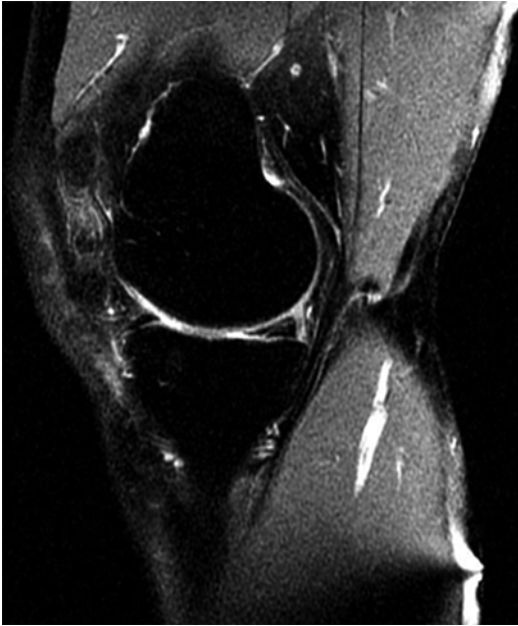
Sagittal MRI image shows meniscus tear
